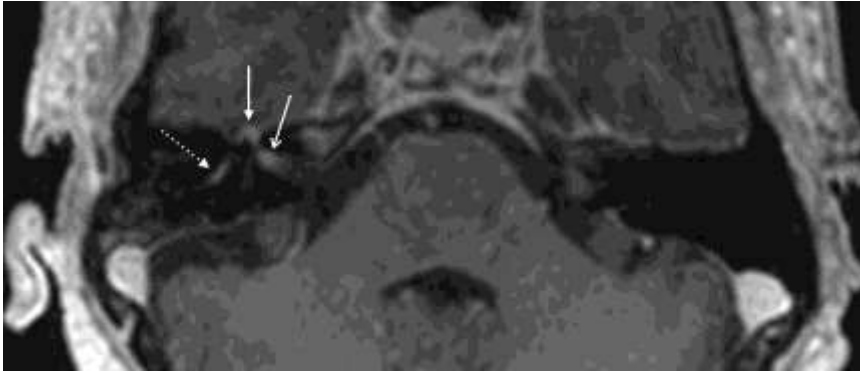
Facial nerve neuritis in a patient with varicella zoster virus reactivation; axial MPR from a 3D T1-weighted fast spoiled gradient echo showing enhancement of the labyrinthine (empty head arrow), tympanic/geniculate ganglion (arrow) and mastoid (dotted arrow) segments of the facial nerve.
